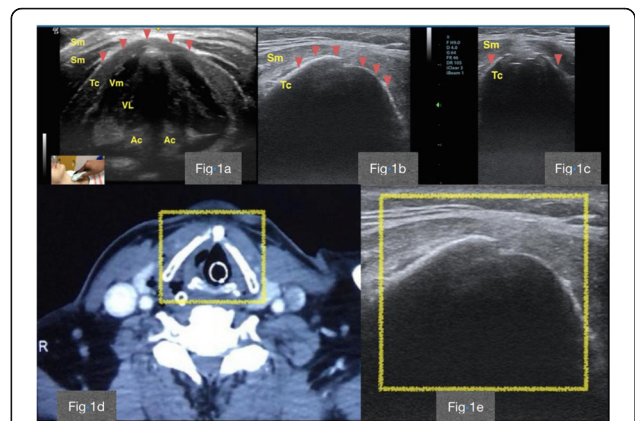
(abstract P339). Figure 1a: Normal sonoanatomy in transverse scan. Figure 1b: Discontinuity of anterior cortex of thyroid cartilage with surrounding tissue oedema in transverse plane. Figure 1c: POCUS image of transverse section of airway showing airway mucosa disruption with a displaced thyroid cartilage. Sm- sternocleidomastoid muscle; Tc-thyroid cartilage; Vm-vocalis muscle; VL-vocalis ligament; AC- arytenoid cartilage. Figure 1d: A Computerised Tomography (CT) scan image shown defect in posterolateral wall of trachea with fracture of right anterior lamina of thyroid cartilage and superior cornu of left thyroid cartilage. Figure 1e: Figure of POCUS airway of thyroid cartilage in relation to the CT scan image
